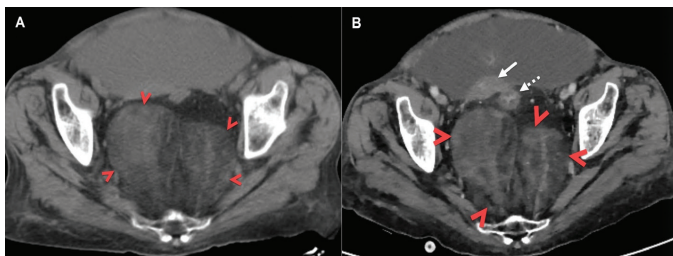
Axial unenhanced and (B) contrast-enhanced computed tomography image of the pelvis demonstrate a heterogeneous, well-defined and contrast-enhanced fatty mass with solid components in the presacral space
